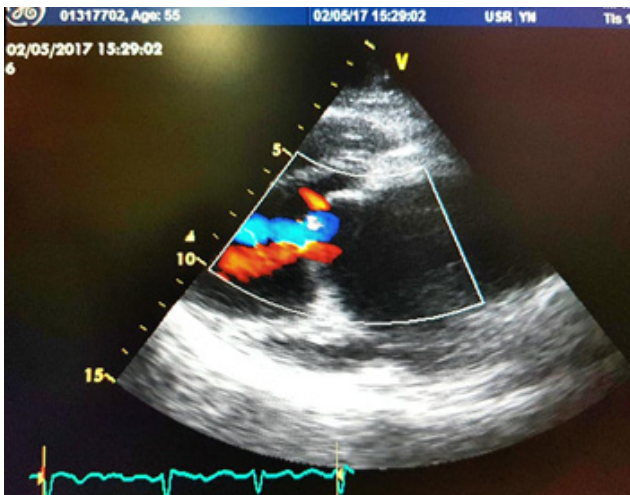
Echocardiography showing severe mitral stenosis
